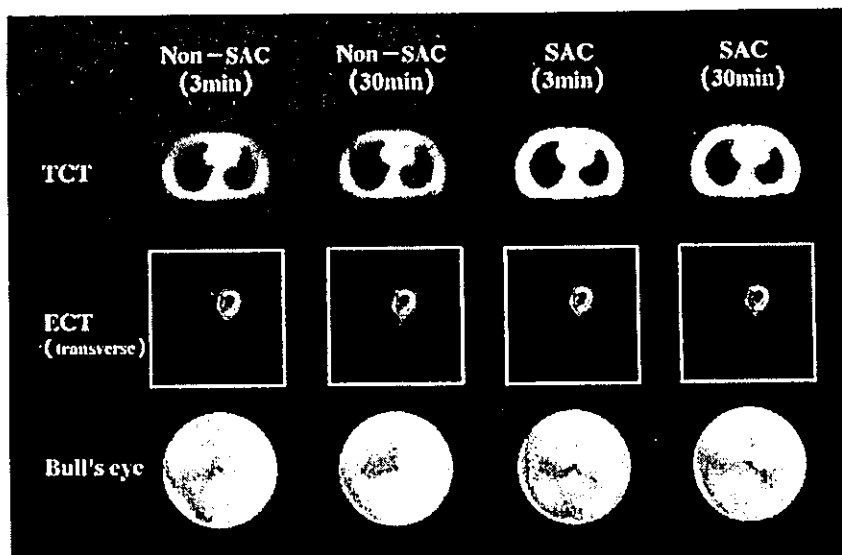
The upper panel shows attenuation maps (TCT images), the middle panel SPECT images (ECT images), and the lower panel polar maps (Bull's eye images) of a human subject. Images corrected with Non-SAC (3 min, 30 min) and SAC (3 min, 30 min) are shown from left to right for ECT and Bull's eye, respectively.
